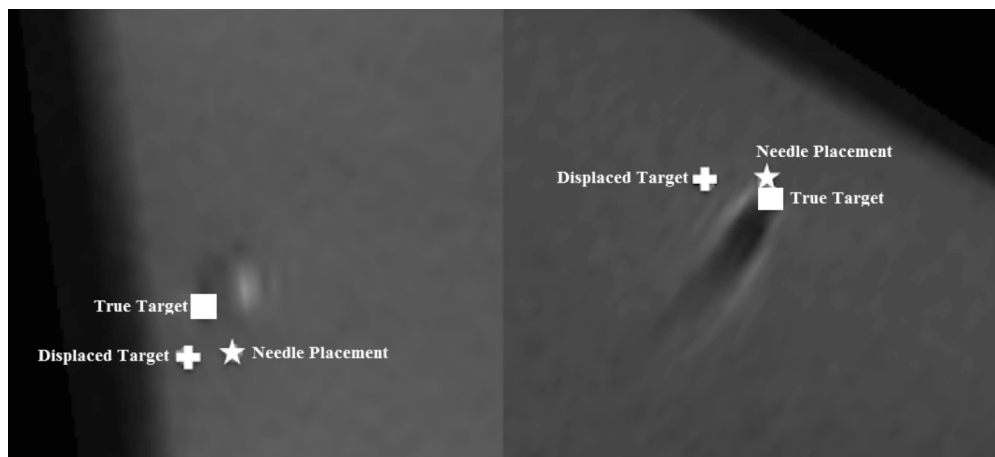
Highlighted MR images from free-hand (left) and robotic (right) probe placements. The tip of the probe artifact (marked as “Needle Placement” with white star) in both images. Note the true target (“True Target” with white square) is aimed more precisely in the robotic approach than in the free-hand approach, compared to when the target shifted due to artificial organ motion (“Displaced Target” with white plus) which is missed by both approaches by similar degree of distance.
